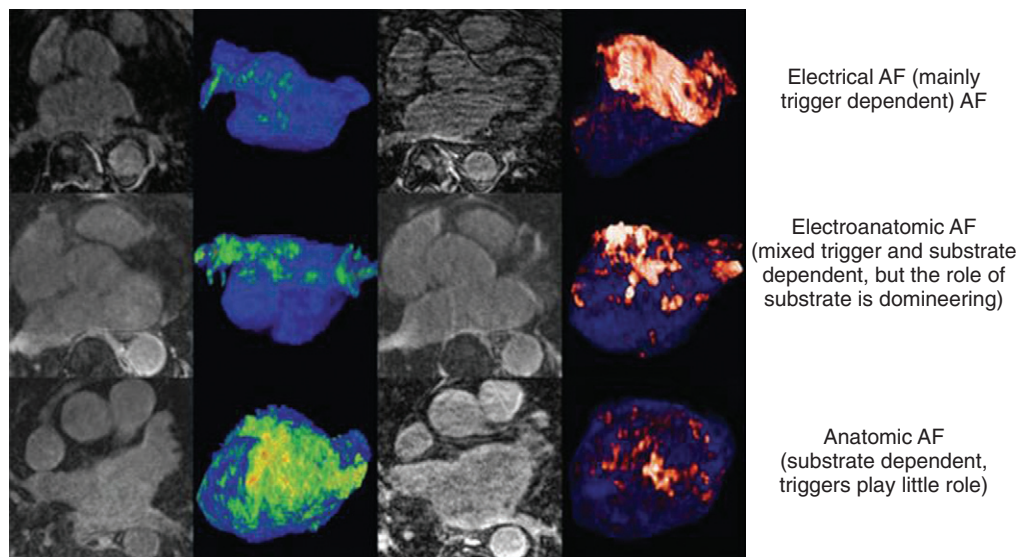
Stages of progression of atrial fibrillation assessed by delayed-enhancement magnetic resonance imaging. (From Mahnkopf C, Badger TJ, Burgon NS, et al: Evaluation of the left atrial substrate in patients with lone atrial fibrillation using delayed-enhanced MRI: Implications for disease progression and response to catheter ablation, *Heart Rhythm* 7:1475–1481, 2010.)
